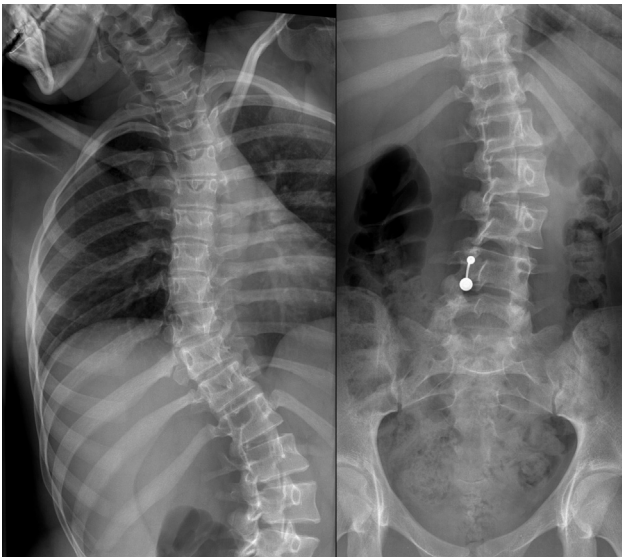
Preoperative bending radiographs of the patient in Fig. 2.
